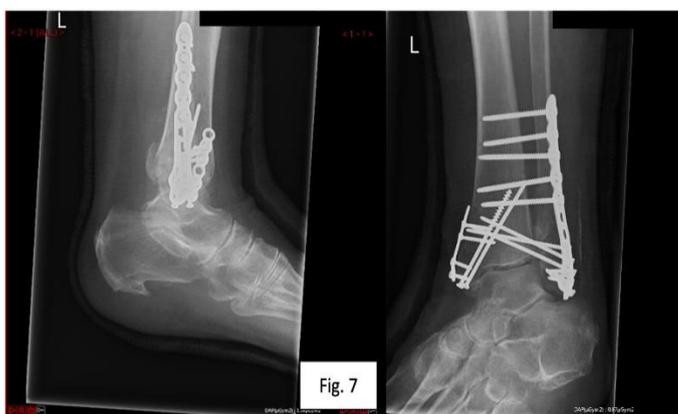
Post-operative anterior-posterior and lateral plain film X-rays of revision ORIF
